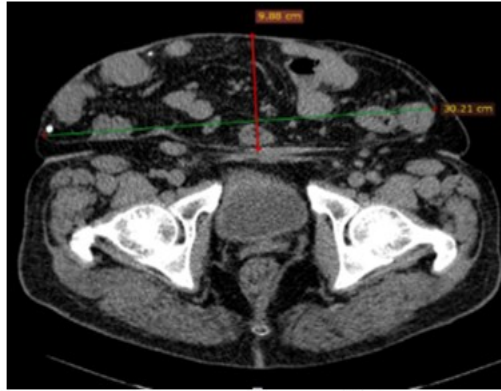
CT (Cross-sectional Plane).
